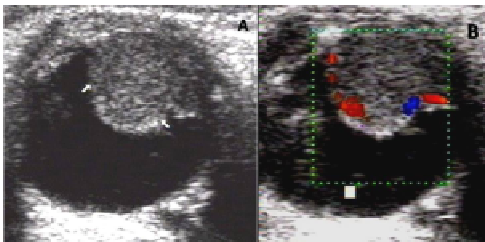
US reveals (A) a mushroom shaped hypoechoic mass arising from the choroid showing a hyperechoic rim (arrows) in an elderly patient (B) which shows vascularity on Color Doppler suggestive of choroidal melanoma.
